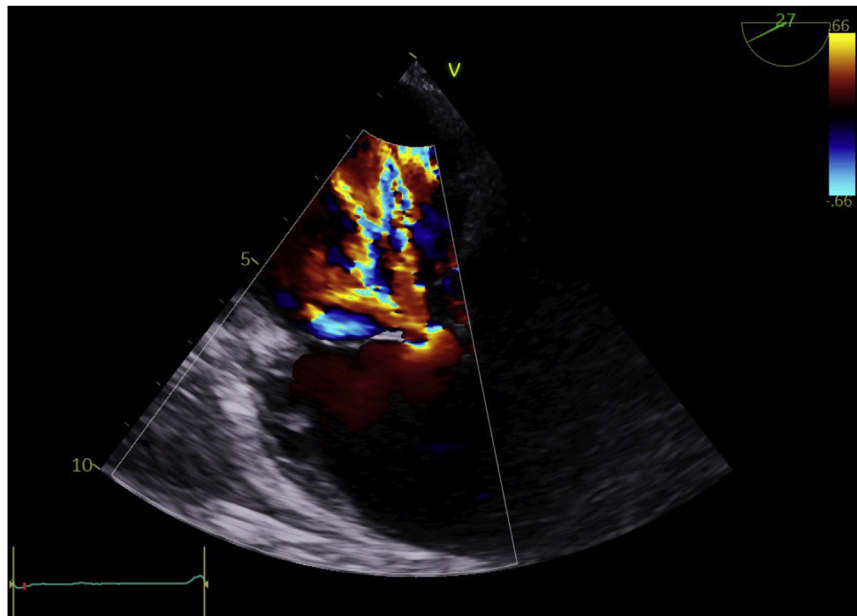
Transesophageal deep esophageal RV focused view showing a broad tricuspid regurgitant jet.
